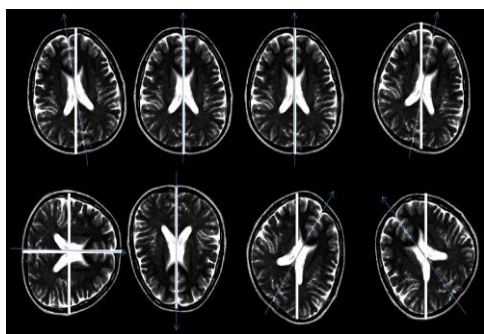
Images of head motions in MRI.
